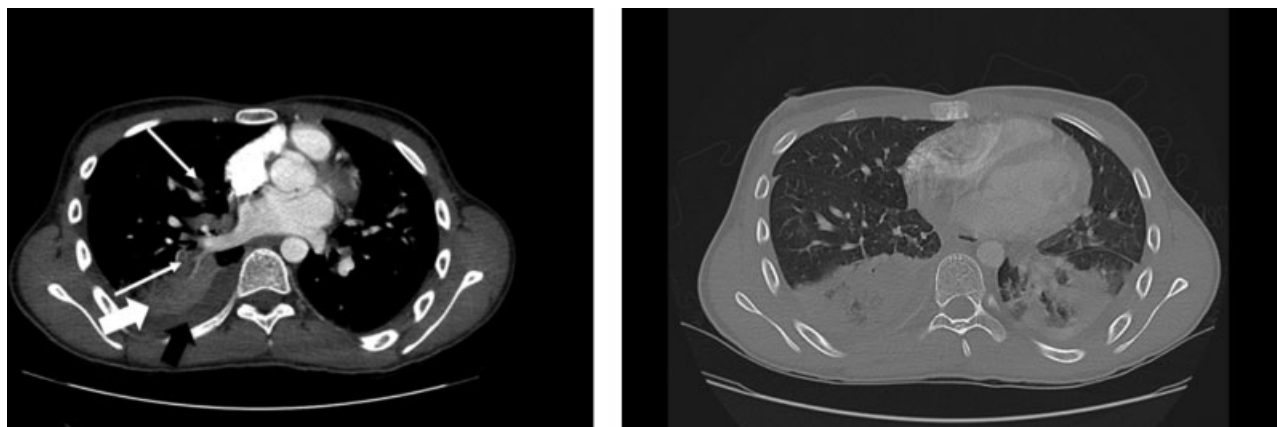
(A) Axial computed tomography angiography image showing right middle and lower lobe pulmonary emboli (small white arrows) with right-sided pleural effusion (large black arrow) and consolidation (large white arrow). (B) Computed tomography lung window at a more caudal slice demonstrates bilateral consolidation and pleural effusion.
